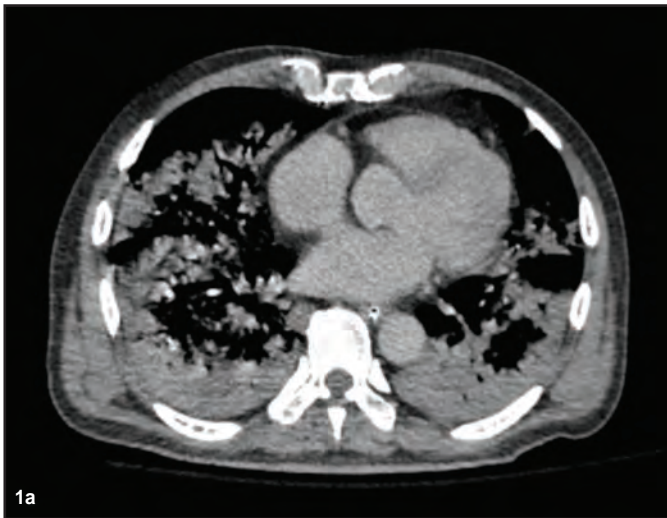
CTA Thorax; axial images in soft tissue window (1a) and lung window (1b) respectively showed diffuse consolidative changes at both lung fields, predominantly at the dependent aspect associated with surrounding ground glass changes, likely to represent diffuse pulmonary haemorrhages in this case. Other differential diagnosis could be diffuse pulmonary infection / diffuse pneumonia No evidence of active bleeding (not shown in these images).
